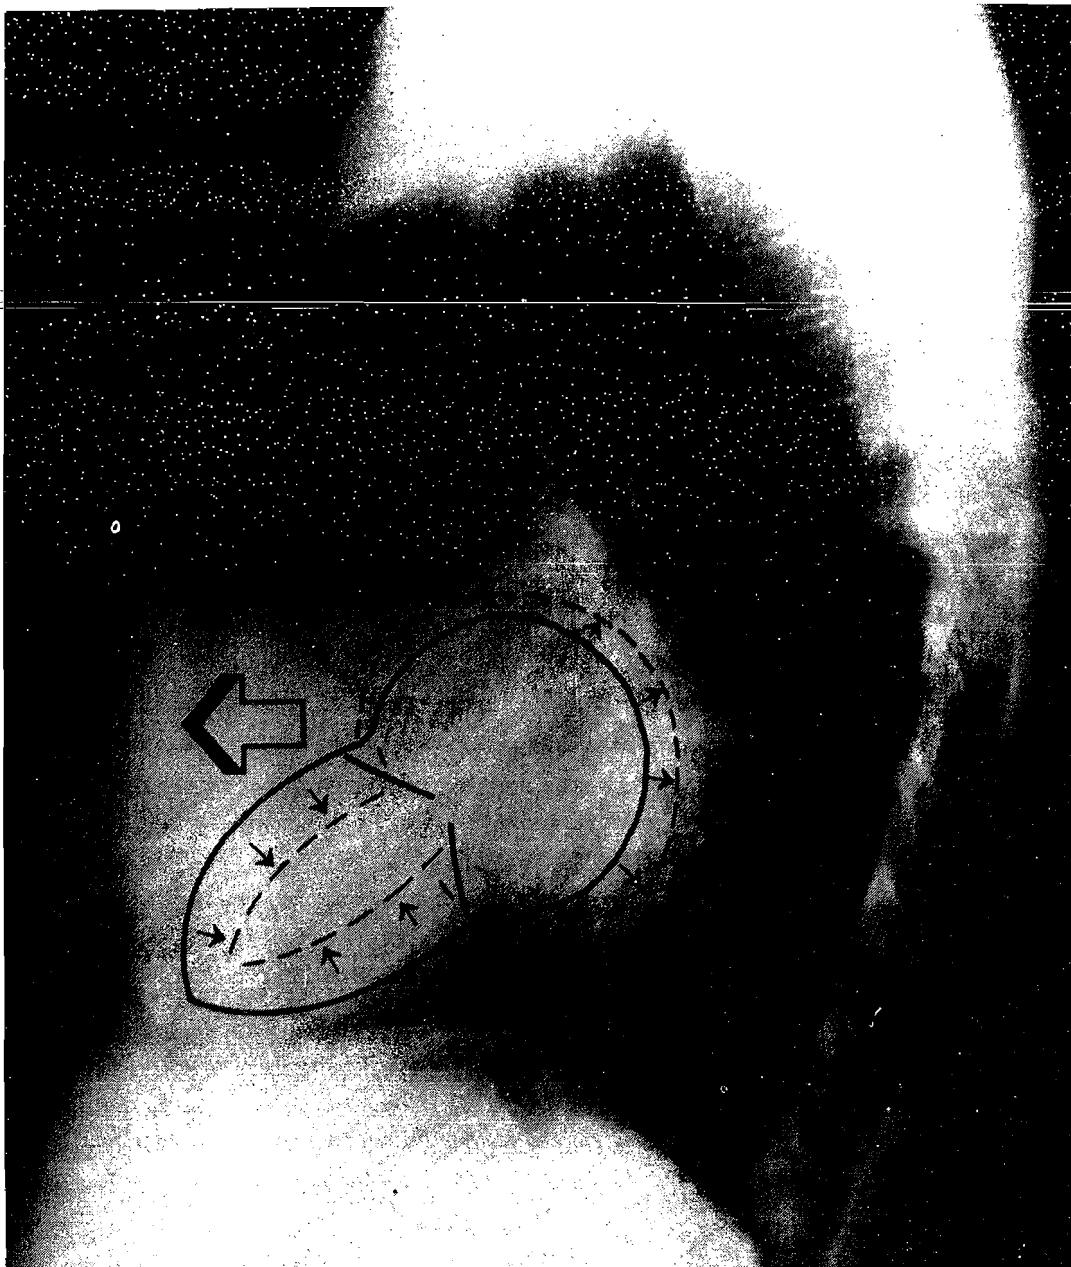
Mechanism of the anterior parasternal thrill in severe mitral regurgitation. During systole a large regurgitant volume fills a dilated left atrium, thrusting the right ventricle forward. This results in palpable anterior displacement of the lower left sternal border, which is late systolic in timing and can be felt as a separate and delayed impulse when compared with simultaneous palpation of the left ventricular apex beat (see Fig. 17-4). (From Abrams J: Precordial Palpation. In *Signs and Symptoms of Cardiology*. Edited by LD Horwitz and BM Groves. Philadelphia, JB Lippincott Co, 1985.)
